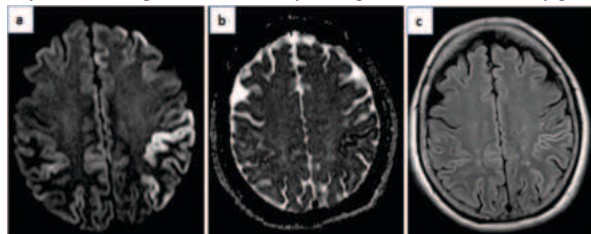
a), b) and c) Gyriform diffusion restriction involving left parietal lobe with corresponding areas shows FLAIR hyper intensities.
